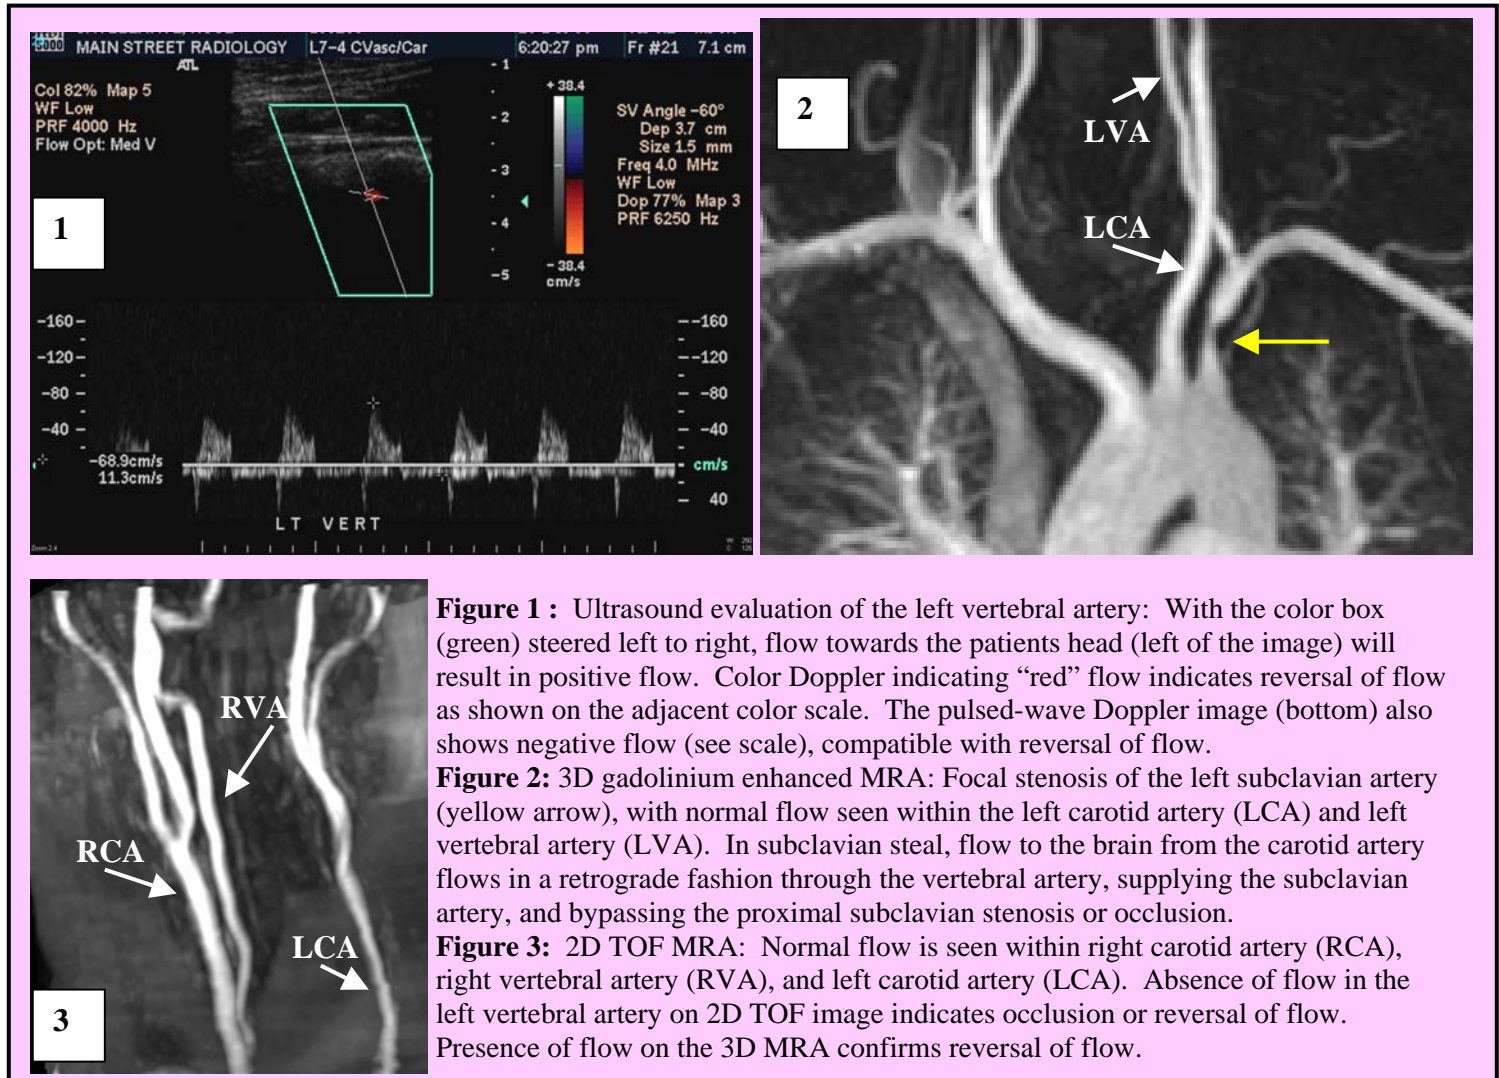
Ultrasound evaluation of the left vertebral artery: With the color box (green) steered left to right, flow towards the patients head (left of the image) will result in positive flow. Color Doppler indicating “red” flow indicates reversal of flow as shown on the adjacent color scale. The pulsed-wave Doppler image (bottom) also shows negative flow (see scale), compatible with reversal of flow.
